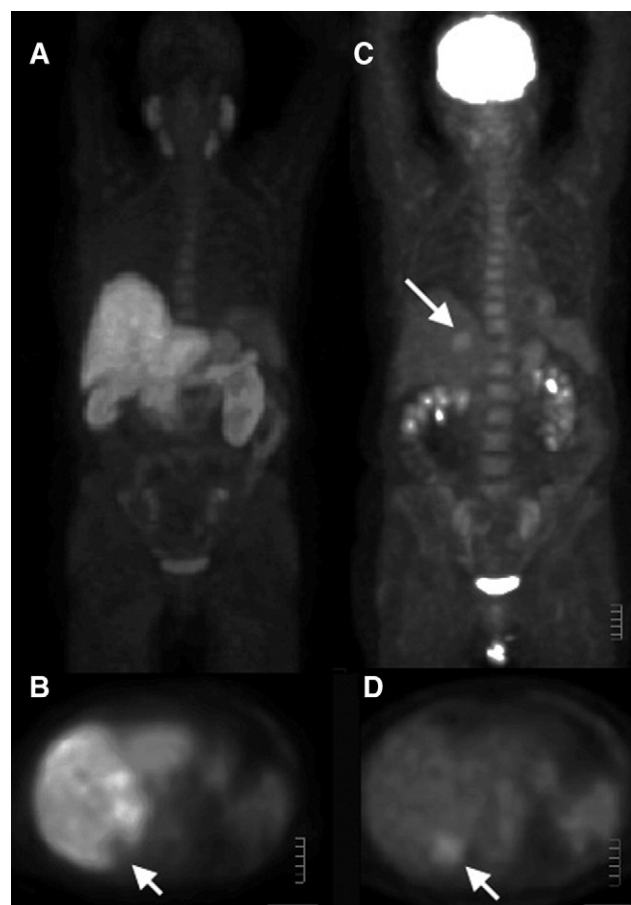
FCH PET (A and B) and FDG PET (C and D) images of a hepatic mass in a patient with a previous history of rectal adenocarcinoma. The mass (arrow) took up FDG and not FCH, appearing photopenic on FCH PET as compared with the surrounding healthy liver tissue. The lesion was confirmed to be metastatic rectal adenocarcinoma at surgery.
